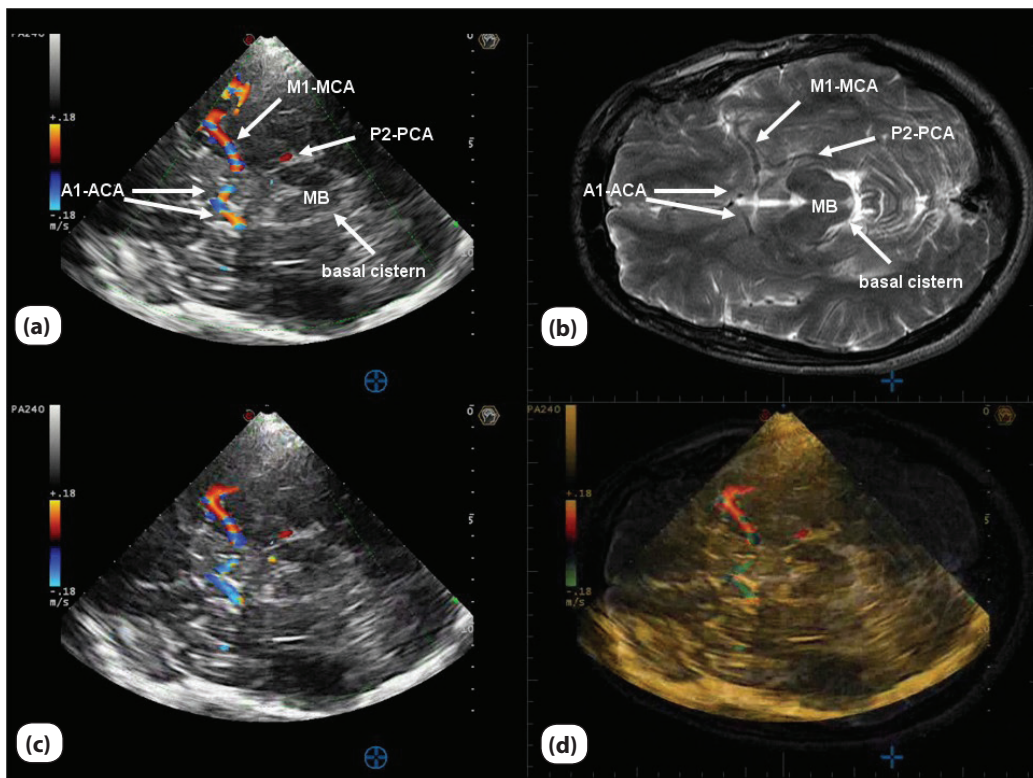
Ultrasound fusion imaging (UFI) overlay function. (a) transcranial color-coded sonography (TCCS) image of the midbrain plane demonstrating the butterfly-shaped midbrain (MB), the hyperechogenic basal cisterns, the ipsilateral P2-PCA, and M1-MCA-segment as well as both A1-ACA segments; (b) corresponding T2-weighted MR image with exactly corresponding structures; (c) identical TCCS image; (d) fused overlay image showing exact match between both image modalities.
